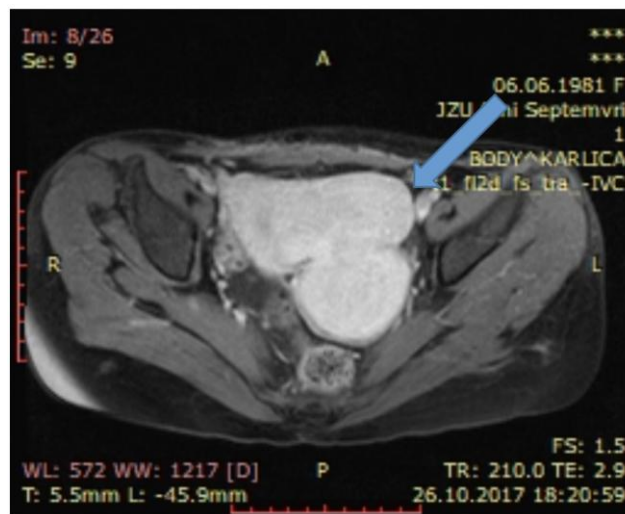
Pelvic MRI; T1 FS contrast-enhanced axial MRI of uterus pre embolisation shows 2 large intramural hypervascular fibroids (arrow) in the left side of uterus body with a displacement of cavum uteri
